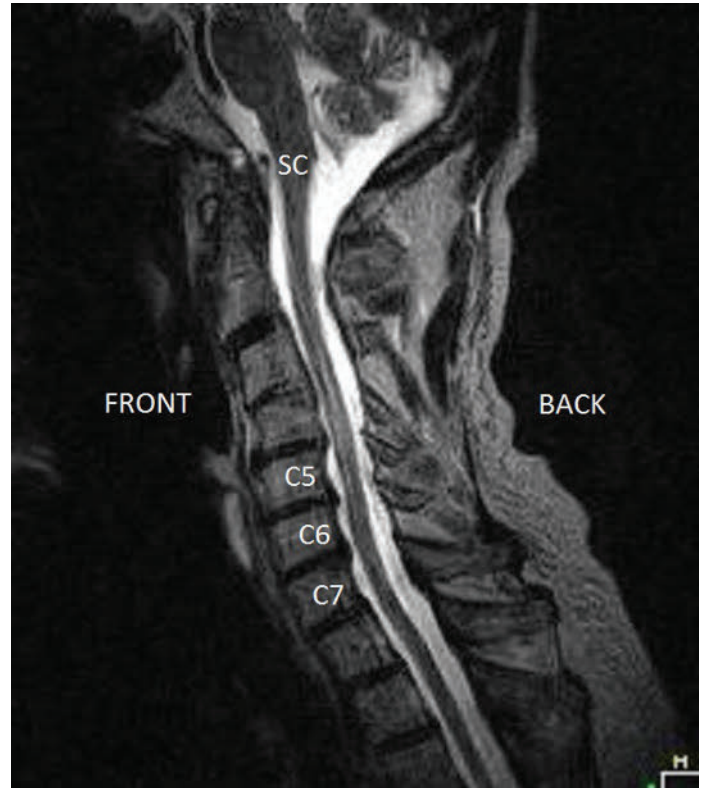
Preoperative T2-weighted sagittal (side view) MRI of the cervical spine with the patient facing to the left. Degenerative changes with disc herniations and bone spurs indenting the fluid space surrounding the spinal cord (SC) at the C5-C6 and C6-C7 levels.
